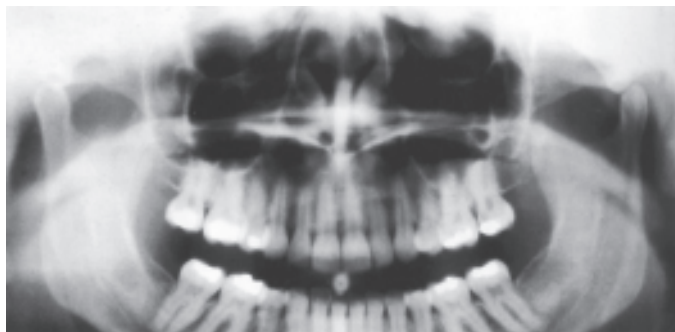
Panoramic radiograph showing both condyles
